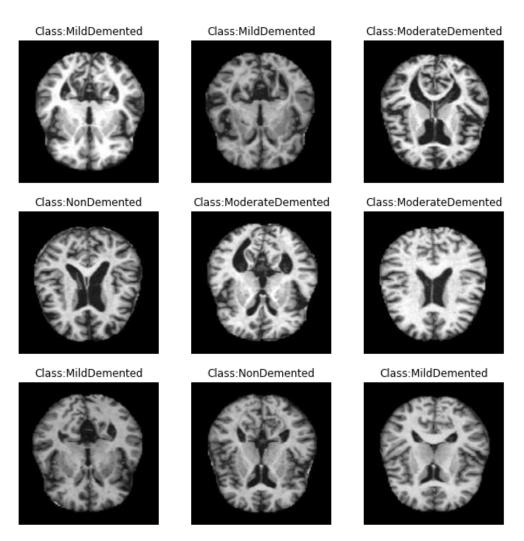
Sample MRI scans.
